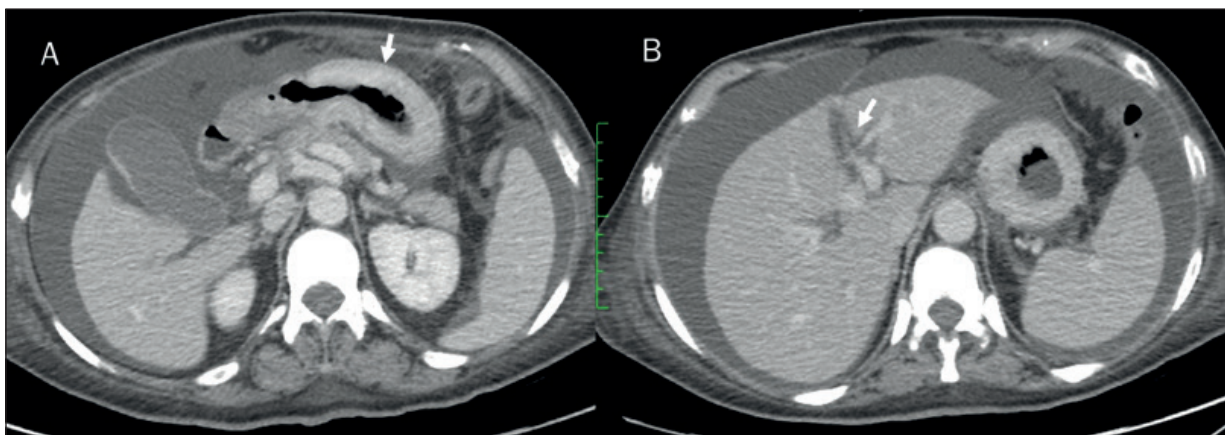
Patient assessed on contrast CT study with Gastric Cancer (A; arrow) and PC with peribiliary and falciform ligament involvement (B; arrow).
